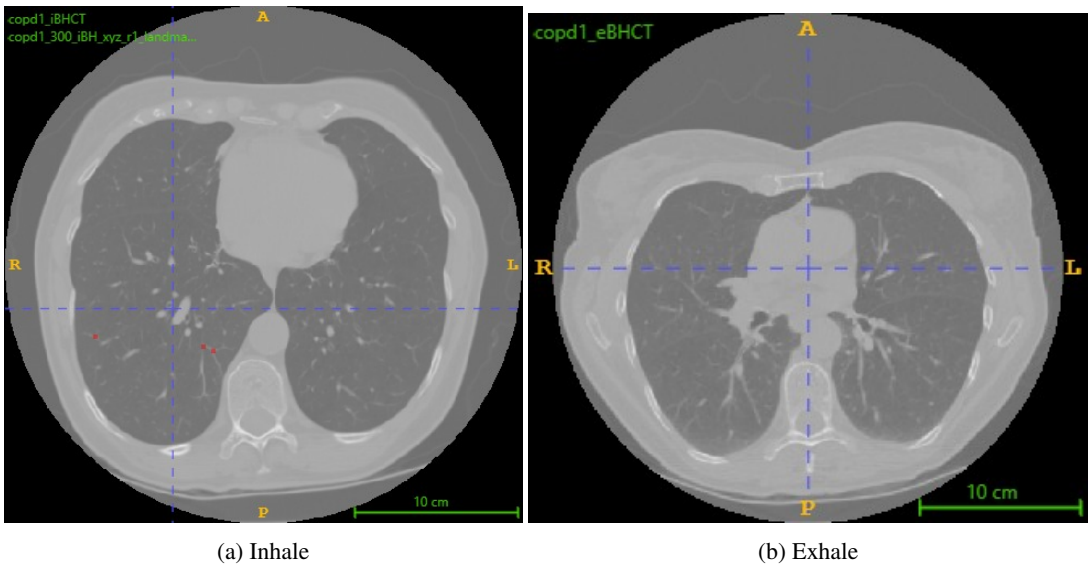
The inhale eBH-CT (left) slice and the exhale iBH-CT (right) slice of COPD1 image with corresponding landmark points.
